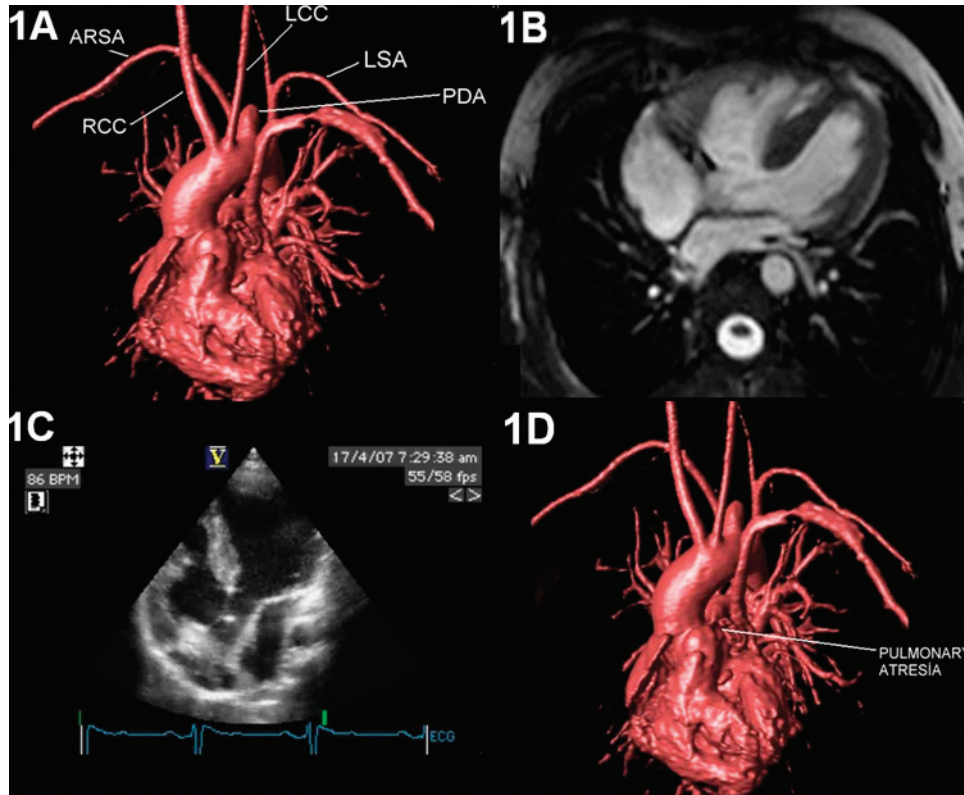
Cardiac computed tomography scan revealing the arcus aorta and its branches (A), ventricular septal defect (VSD) (B), and pulmonary atresia (D). C, Echocardiogram showing the VSD. RCC indicates right common carotid artery; ARSA, aberrant right subclavian artery; LCC, left common carotid artery; LSA, left subclavian artery; PDA, patent ductus arteriosus.
